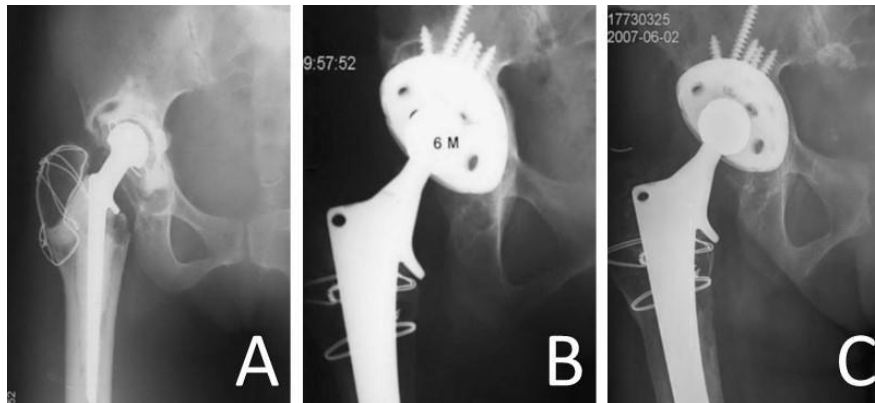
A: preoperative x-ray with loosening of the acetabular component. B: 6 months after acetabular cup revision with deep frozen morselized allograft and a hemispherical cementless acetabular cup. C: 144 months postoperatively, showing the incorporation and remodeling of transplanted morselized allograft, with no signs of radiolucency, and the cup was well fixed ⁽⁴⁹⁾.
